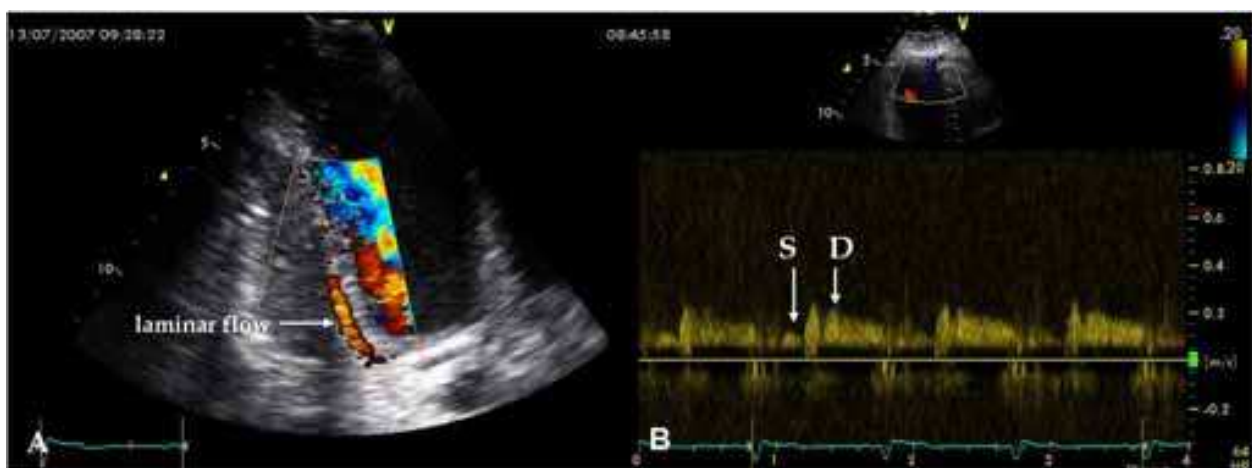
Doppler examination in the PDA: A - laminar flow in the PDA is presented by red linear structure on color Doppler map; B - velocity pattern registered by pulse-wave Doppler; s - systolic phase, d - diastolic phase.
